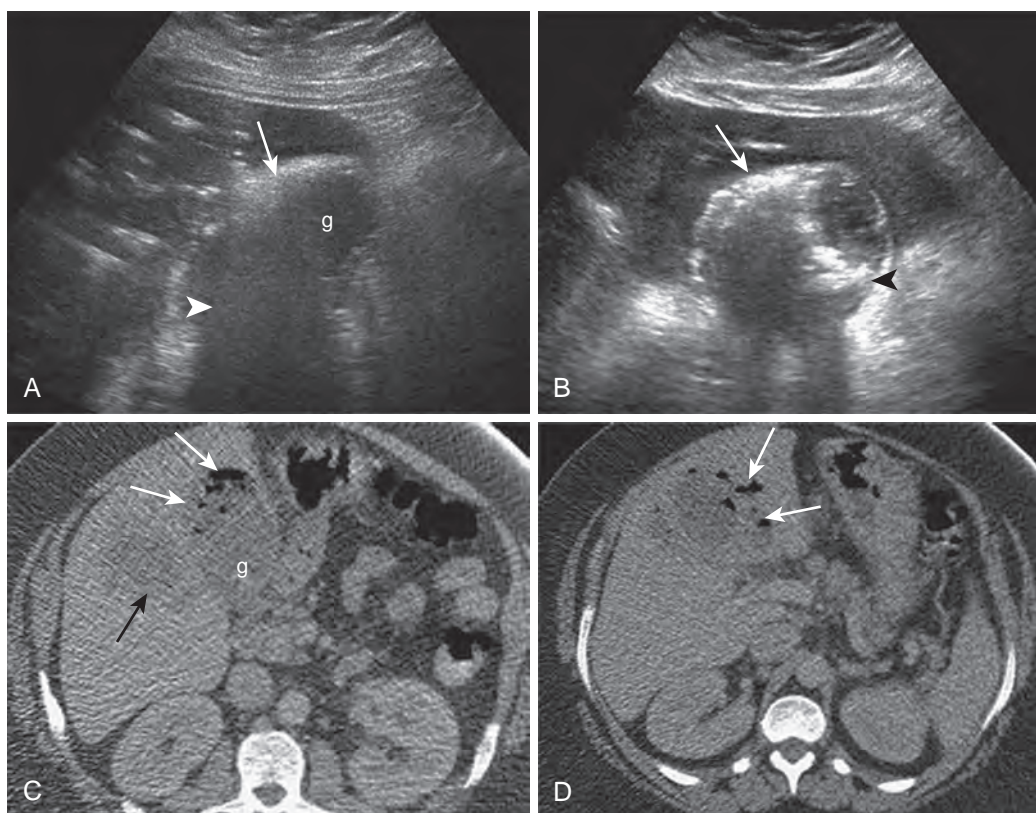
Emphysematous cholecystitis: ultrasound and CT features. A. Sagittal gallbladder (g) scan demonstrates an arc of increased echogenicity (arrow) in expected location of the gallbladder wall. This is associated with “dirty” posterior acoustic shadowing (arrowhead), suggesting intramural gas. B. Transverse image demonstrates intramural gas (arrow) and intraluminal echogenic foci with posterior acoustic shadowing (arrowhead), indicating gallstones. C. Noncontrast CT demonstrates gas (white arrows) within lumen and wall of gallbladder (g). Low-attenuation area in the adjacent liver is due to an abscess (black arrow). D. Gas (arrows) is present in the pericholecystic soft tissues.
